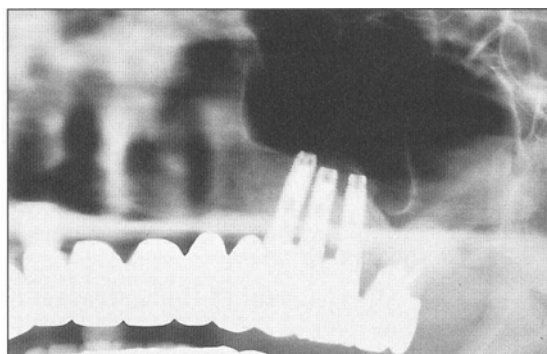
Three-year postloading radiograph. One 15-mm and two 13-mm implants were placed.
